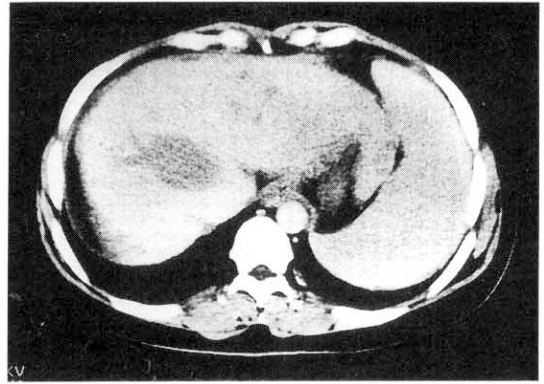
Abdominal computed tomography showing ill-defined large inhomogeneous mass filling the entire right lobe of the liver.
